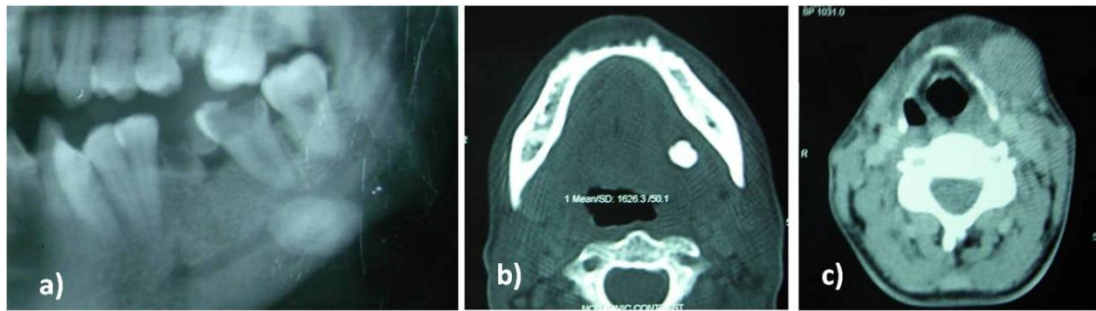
a) Cropped panoramic radiograph showed a well defined radiopaque structure at apical area of 37. b) CT scan showed a single hyper dense area c) CT (soft tissue window) scan showed enlarged left Submandibular gland with contrast enhancement.
